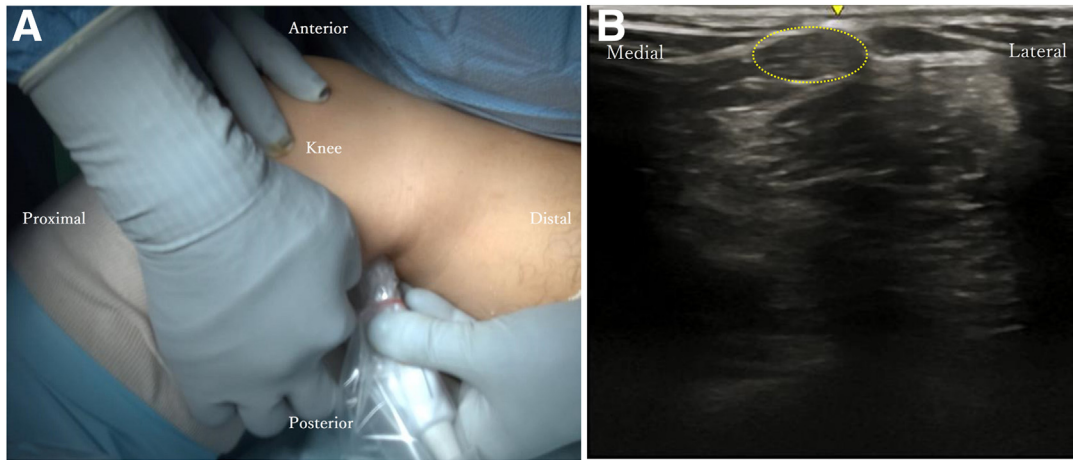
(A) Identification of the semitendinosus tendon. Left leg in a figure-4 position with the patient supine. Before making an incision, we confirm the location of the semitendinosus tendon by placing an ultrasound probe over the palpated tendon at the posteromedial aspect of the popliteal fossa. (B) Short-axis ultrasound image of the semitendinosus tendon (encircled).
